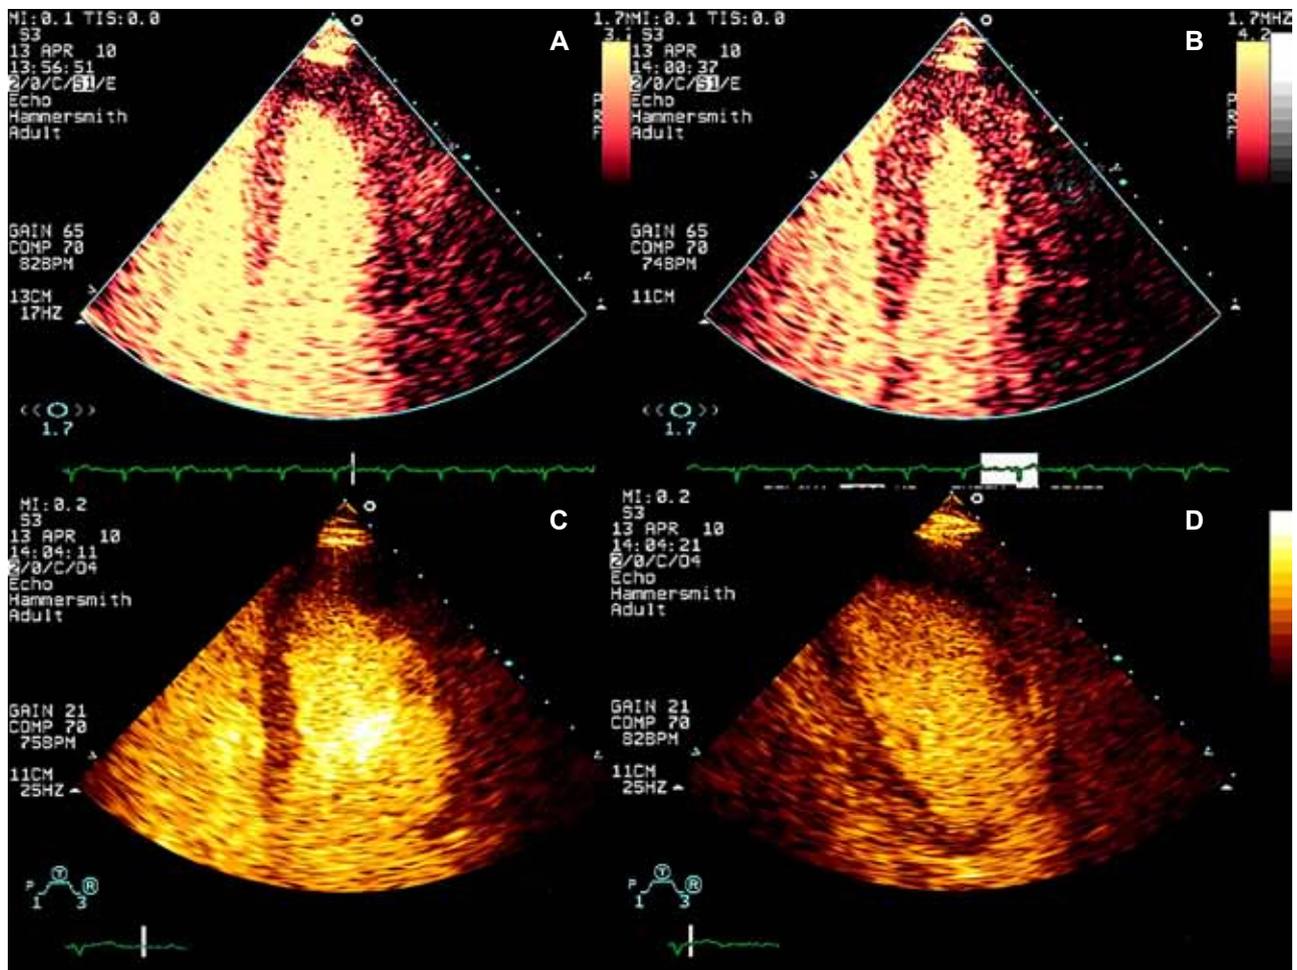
Myocardial perfusion imaging did not demonstrate a perfusion deficit (A, B). Dobutamine stress echocardiography showed good ventricular function at peak stress (C, D).
